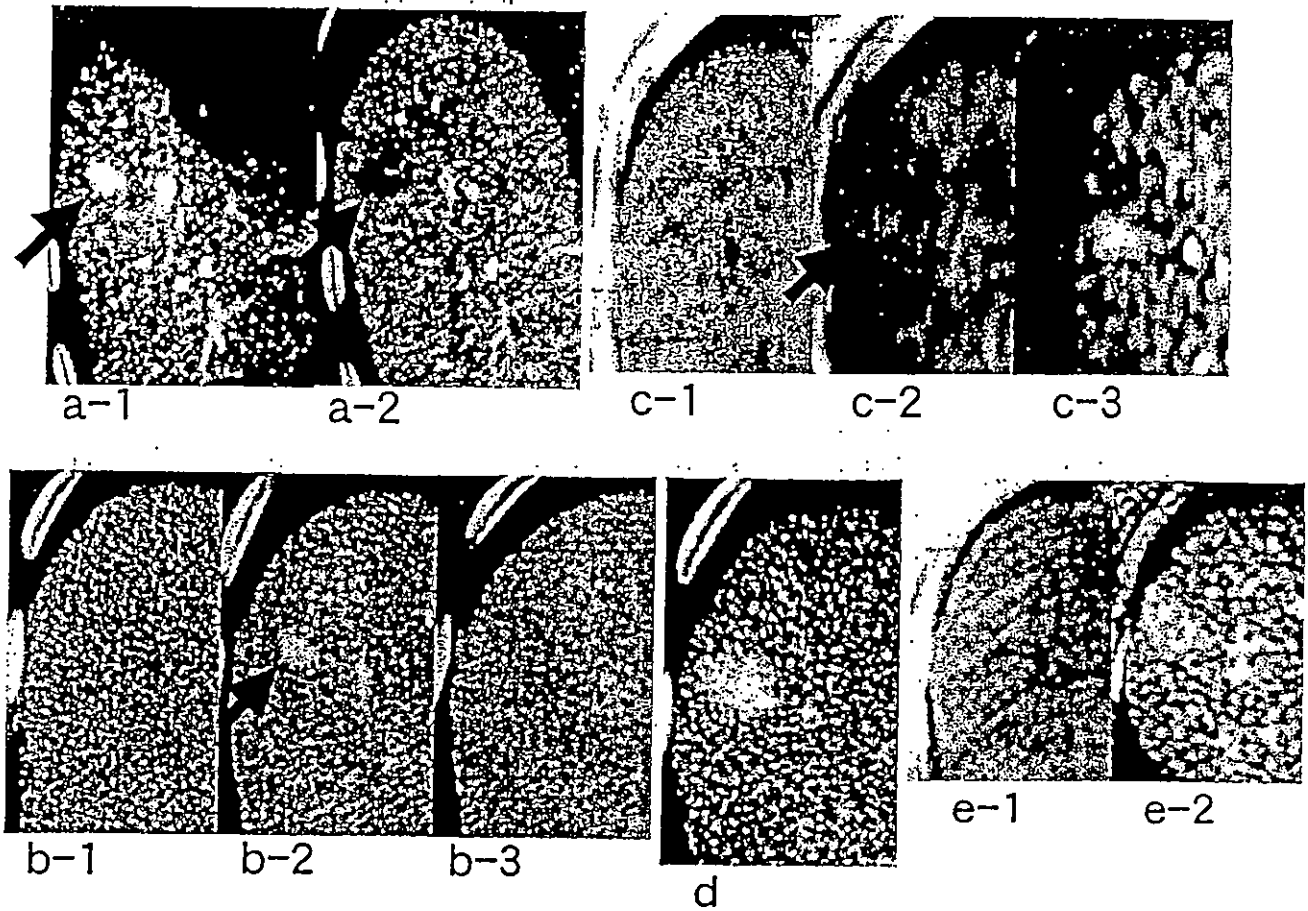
Example of TSS without TAE treatment and with tumor growth in a patient without HCC. a-1, Computed tomographic arteriography (CT-A); a-2, CT-arteriportography (AP); b-1, precontrast CT; b-2, early-phase CT; b-3, delayed-phase CT; c-1, T1-weighted (wt) magnetic resonance imaging (MRI); c-2, T2-wt MRI; and c-3, early phase of MRI obtained when TSS was detected. d Early-phase CT; e-1, T1-wt MRI; and e-2, T2-wt MRI obtained when tumor growth was noted. The TSS shown by the arrow in a-1 and the arrow in c-2 was 0.8 cm in diameter and located inside. At first, the TSS showed a high signal on CT-A, low signal on CT-AP, high signal on dynamic CT obtained in the arterial dominant phase, slightly high signal on T2-wt MRI, and high signal in the early phase of dynamic MRI. Tumor growth was noted after 19 months (diameter, 1.2 cm)
